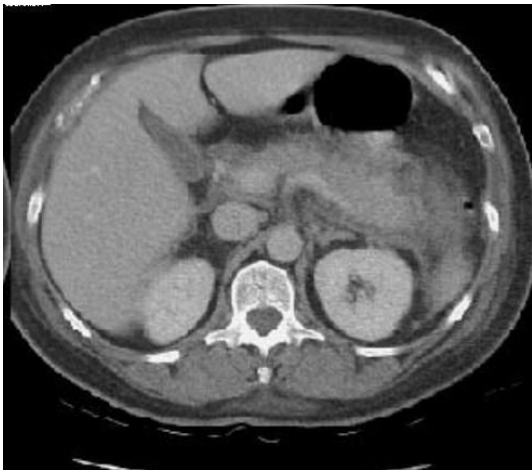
CT showing features of Acute pancreatitis
